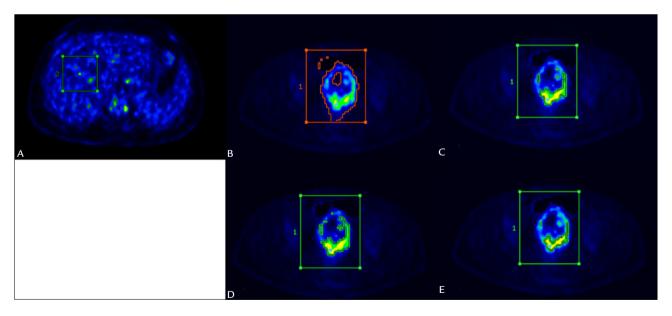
¹⁸F-FDG PET/CT tumor image segmentation methods. A. Region of interest (ROI) placed on a transaxial slice in liver. B. Tumor segmentation generated using 2SD individualized algorithm. C. Tumor segmentation generated using 40% threshold. D. Tumor segmentation generated using 50% threshold. E. Tumor segmentation generated using 60% threshold.
